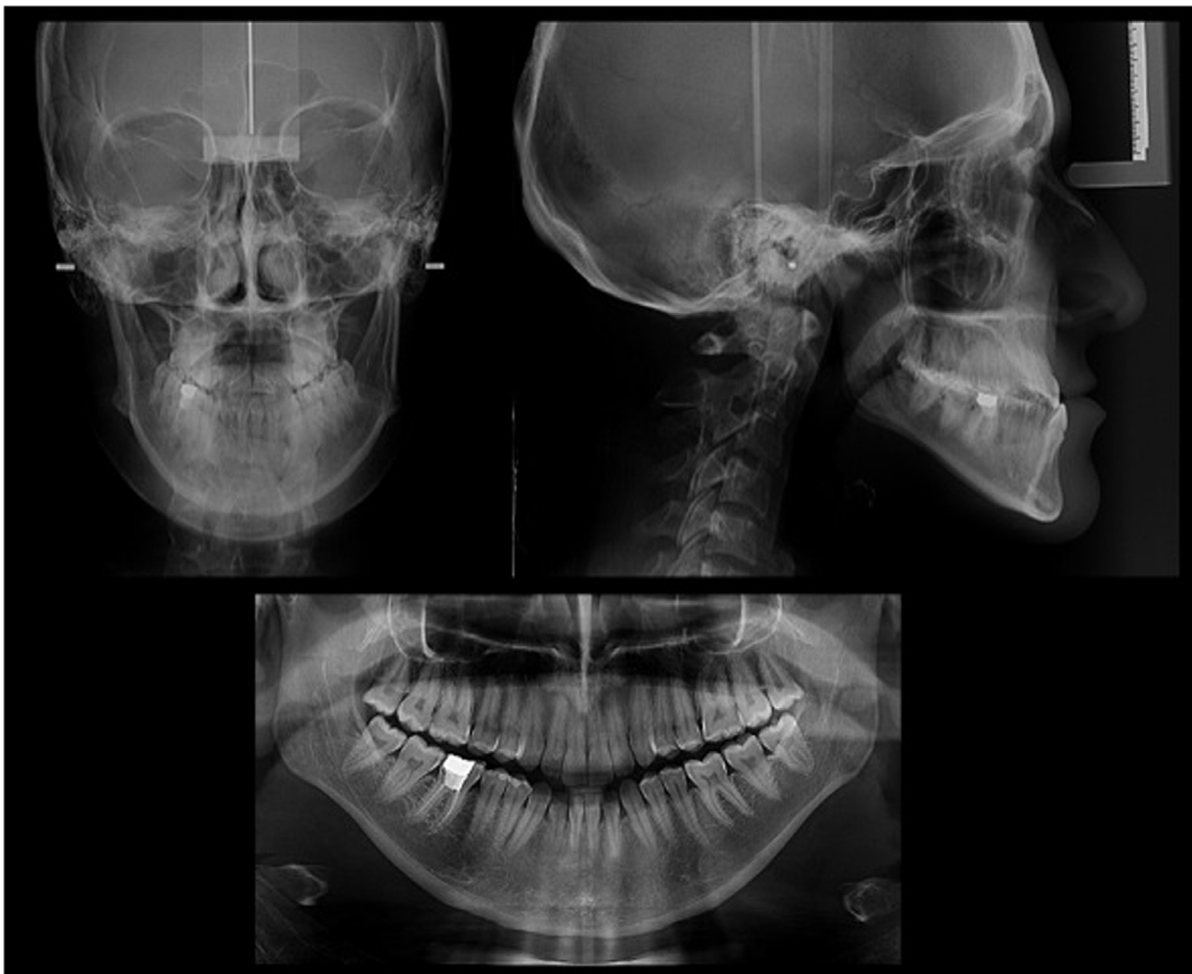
Pre-treatment posteroanterior cephalometric, lateral cephalometric and panoramic radiographs.
